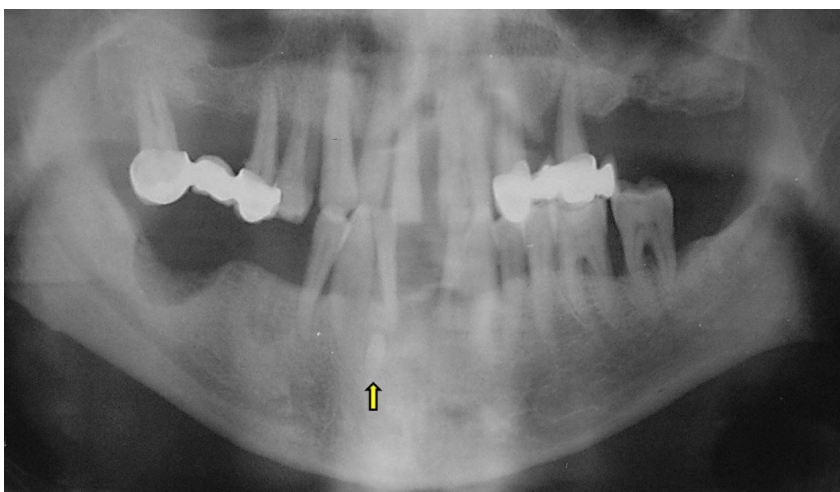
B. Orthopantomographic examination prior the surgical procedure.
